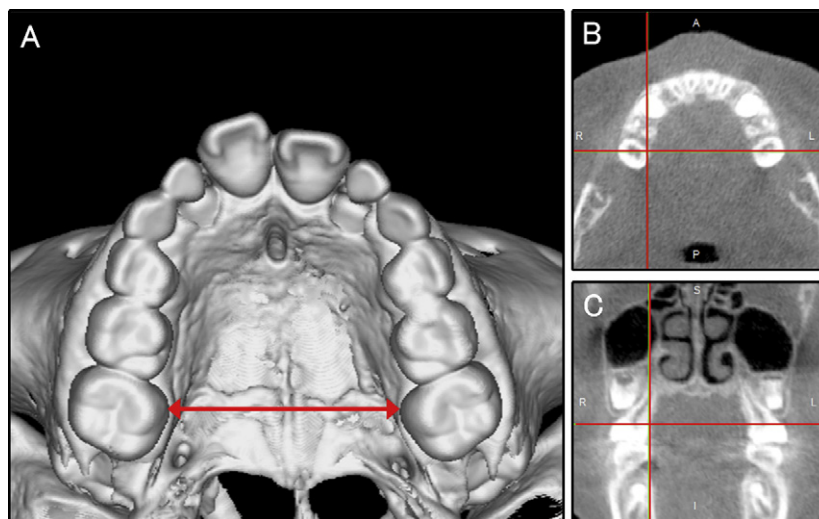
Measurement of 3D intermaxillary molar width: A, locating the intermaxillary molar width at the narrowest portion in a 3D computed tomography reconstruction to set the measurement points in the B, horizontal and C, coronal section images.
